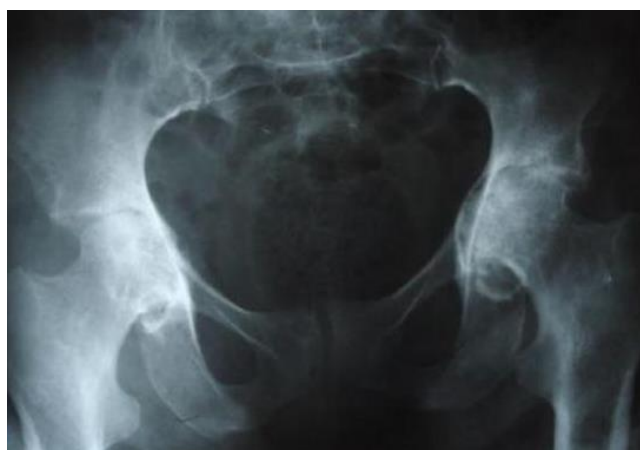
X-ray of the pelvis showing bilateral coxite on RA
